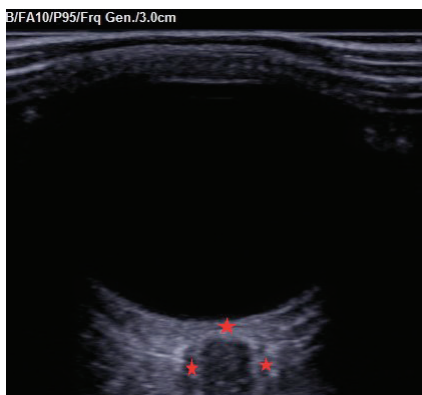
Ultrasonographic view of the optic nerve sheath diameter of a 25-year-old young individual
